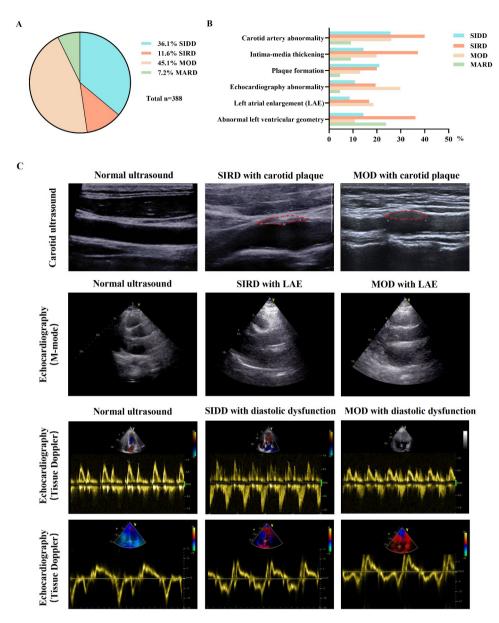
Cardiovascular abnormality in patients with newly diagnosed EOD in cluster classification. A Cluster classification results of EOD patients in START cohort B Detection rate of ultrasound abnormalities in EOD patients by cluster classification C Representative images of carotid artery ultrasound and echocardiography in normal ultrasound group, SIDD, SIRD and MOD subtypes with abnormal echocardiography group. *SIDD* Severe insulin-deficient diabetes, *SIRD* Severe insulin resistant diabetes, *MOD* Mild obesity-related diabetes, *MARD* Mild age-related diabetes, *LAE* Left atrial enlargement
